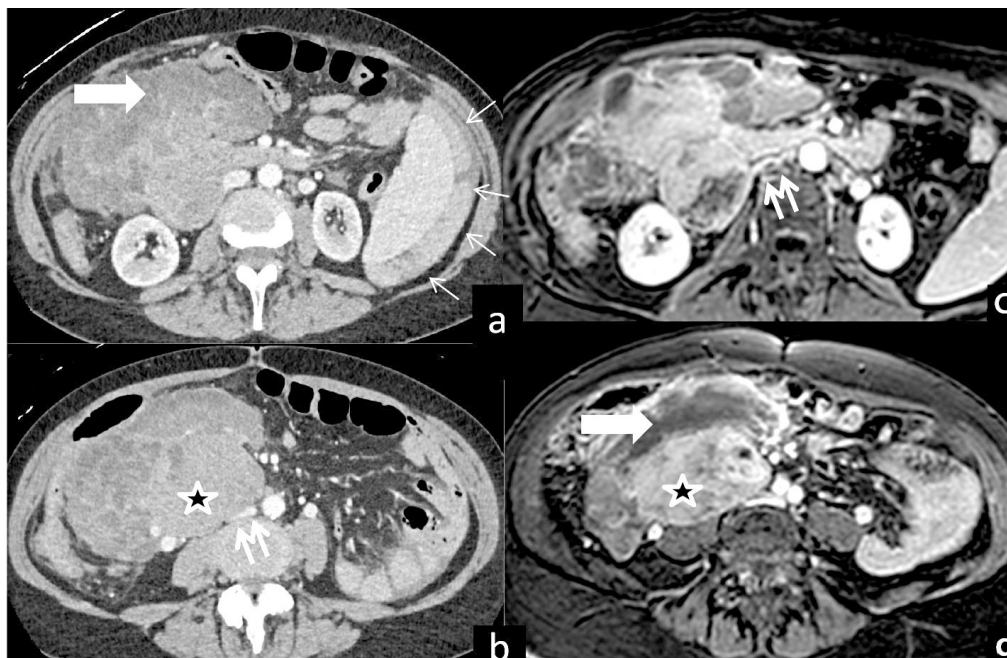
Contrast-enhanced transverse CT image ((a) and (b)) and contrast enhanced fat saturation T1 MRI images (c and d) show a large mass at the level of the right hypochondriac region and right flank strongly adherent to the second portion of the duodenum and IVC, which appears to infiltrate the IVC (arrows). In the mass there are solid components (asterisk in (b) and (d)) and areas of necrosis (arrow in (a) and (c)). The arrows in a point to hemorrhagic perisplenic fluid.
